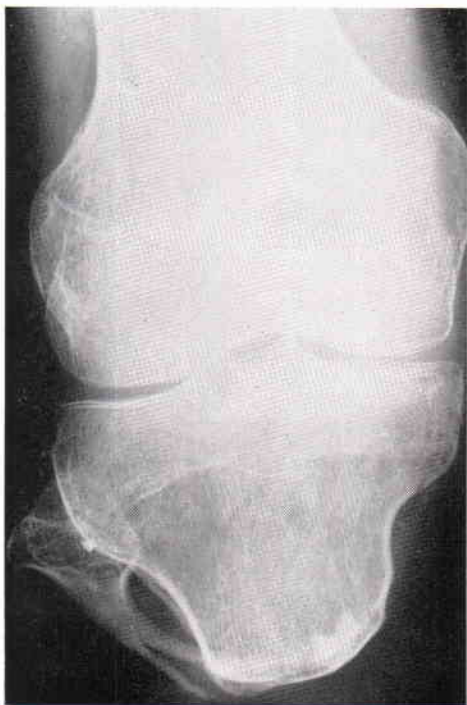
Case 4. Roentgenogram taken shortly after osteoplastic revision to anchor head of fibula in short stump.
